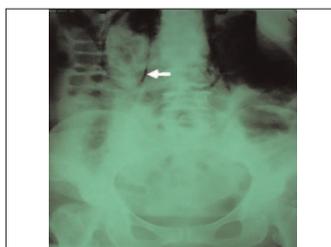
Abdominal plain X-ray. The arrow shows an area of air was around kidneys.
